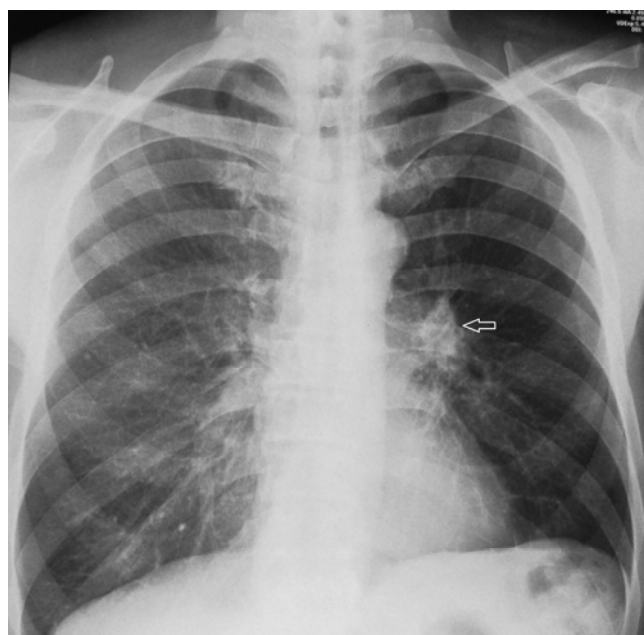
A chest radiograph revealed a well-defined opacity in the left hilar region (arrow).
